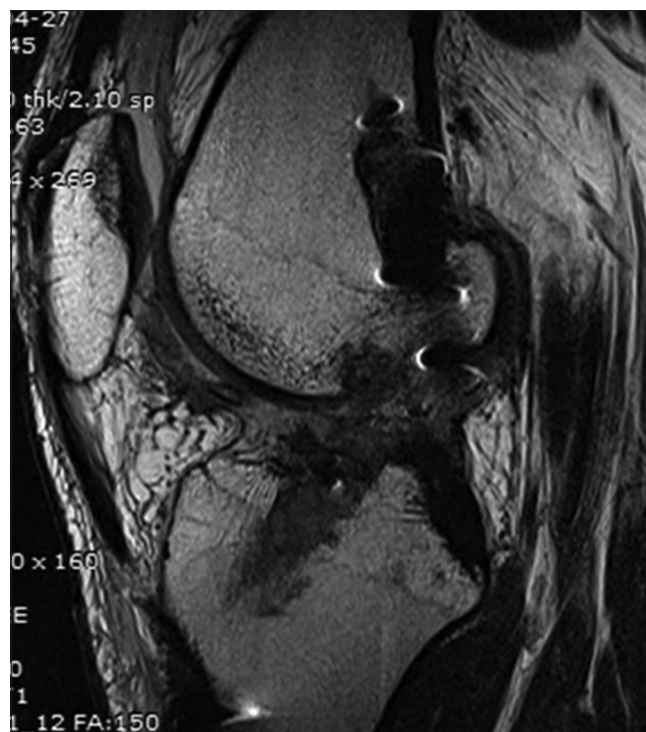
A case of mismatch between the femoral tunnel and the metal interference screw. A postoperative magnetic resonance image of a 20-year-old male patient showing the same aperture between the femoral tunnel and the metal interference screw; however, the axes of the two were different
